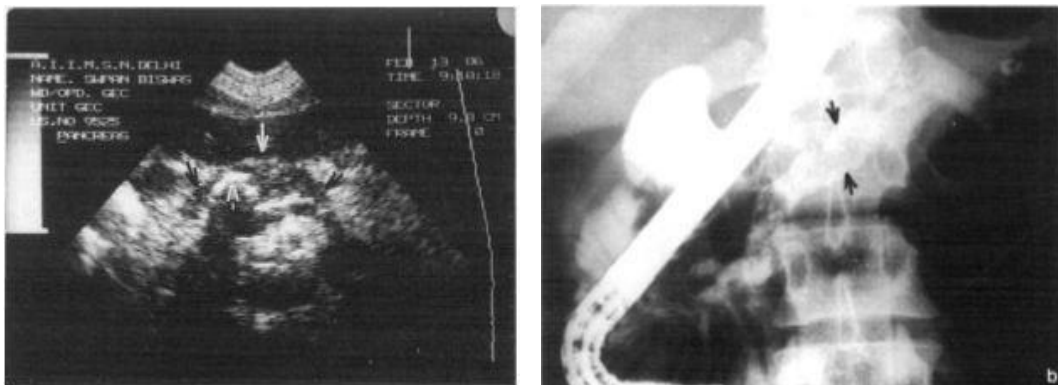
Ultrasonography and Fig. 3. ERCP shows a dilated central pancreatic duct
